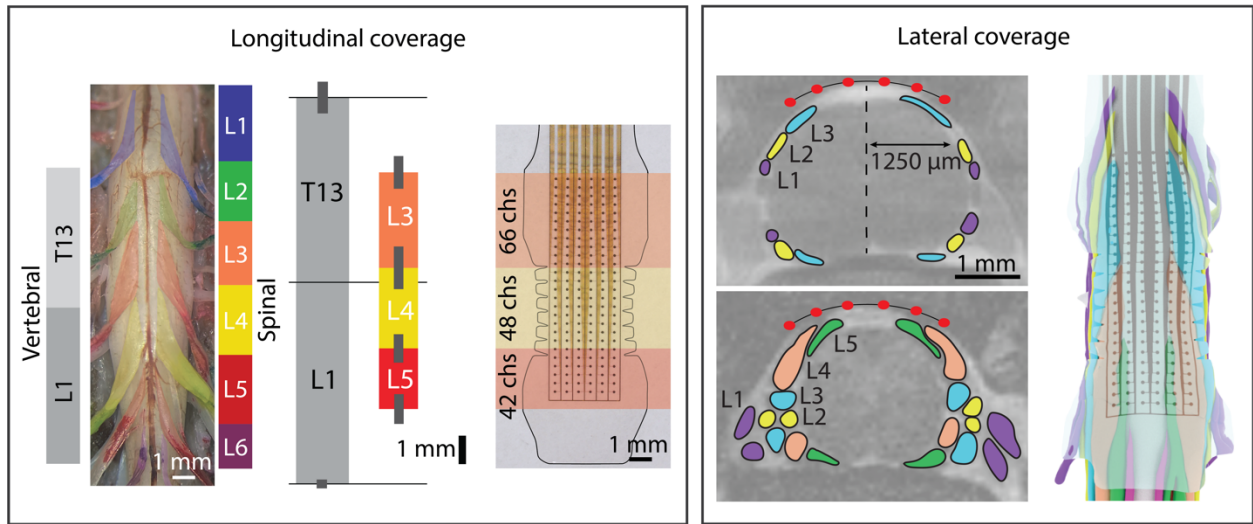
SpineWrap dimensions are tailored to the L3-L5 DREZs. Longitudinal coverage: Dissection of L1 through L6 DRs and their DREZs allowed for determination of optimal longitudinal contact pitch and electrode length. The mean T13-L1 vertebral and L3-L5 spinal segment lengths are shown ($n = 5$). Gray vertical bars indicate ± 1 standard deviation. Lateral coverage: Cross-sectional MRI scans identified the lateral spread of the DREZs and allowed for determination of optimal lateral contact pitch and electrode width.
